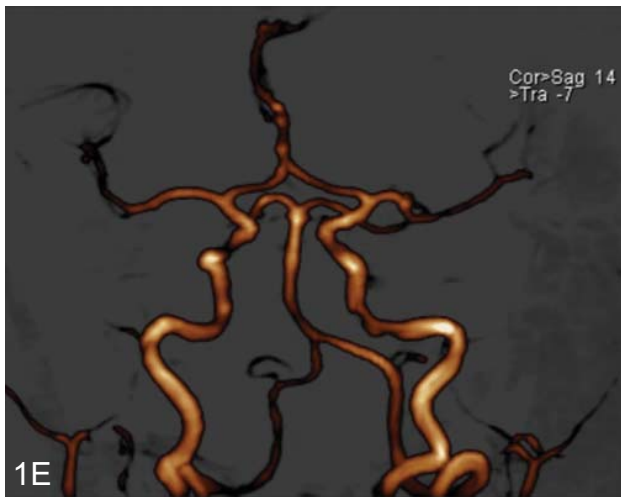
Preoperative MR imaging of the patient with suprasellar meningioma A) The sagittal T1 weighted MR image shows the isointense tumor located at the suprasellar region with intrasellar extension. The tumor was in contact with pituitary stalk inferiorly B) The coronal T1W MR image shows compression of the optic chiasm by the tumor C) The contrast enhanced sagittal MR image shows homogeneously enhancing well defined suprasellar mass with the dural tail sign D) The contrast enhanced coronal MR image shows the superior extension of the suprasellar lesion with displacement of the chiasm. The pituitary gland appears as normal. E) MR Angiography showing no narrowing of the anterior cerebral circulation
